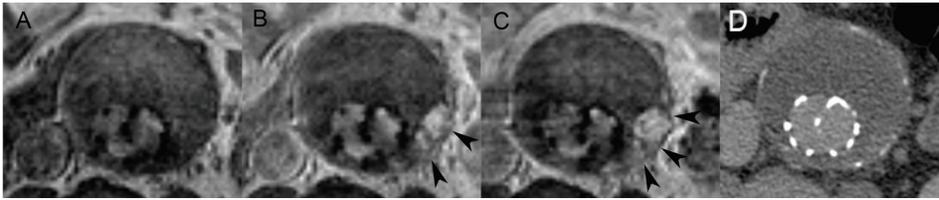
Patient no. 11 in Table 1. Growing aneurysm, 2 years after EVAR. Transverse precontrast(A), early postcontrast(B), late postcontrast(C) T1-weighted spin echo image (TR/TE580ms /15ms) and delayed CT(D) at the same location. Arrowheads in B) and C) point to endoleak. In D) no endoleak is visible. Signal loss around stent in A), B) and C), are because of metal-induced susceptibility artifacts caused by stent components.
